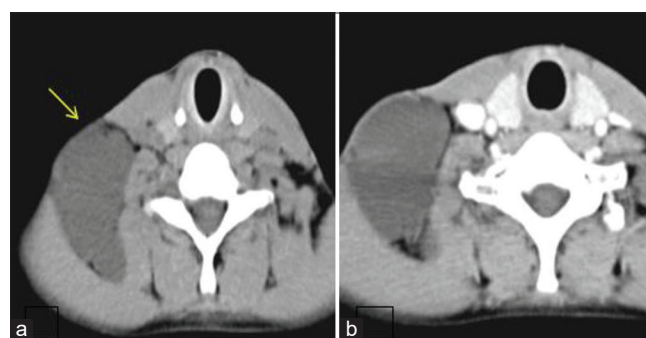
Lymphangioma. (a) A non-contrast CT image shows a well-defined hypodense lesion in the right posterior cervical space. (b) Corresponding contrast CT image shows no enhancement of the lesion
